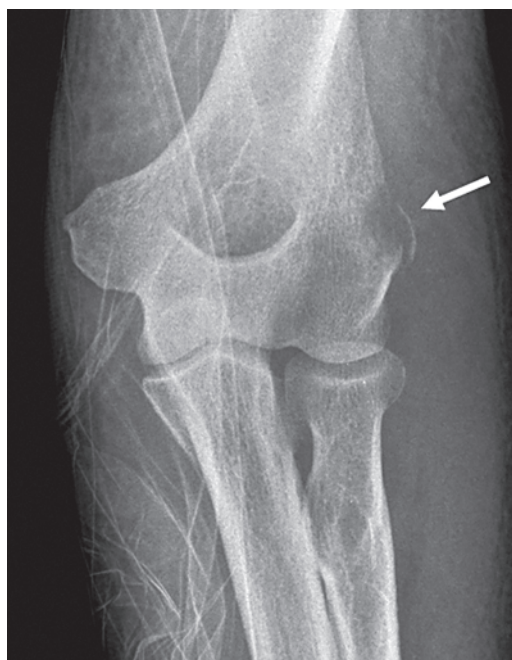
Pathologic avulsion fracture. AP radiograph of the elbow shows an avulsion fracture at the lateral epicondyle of the distal humerus (arrow) with an underlying lytic lesion.
